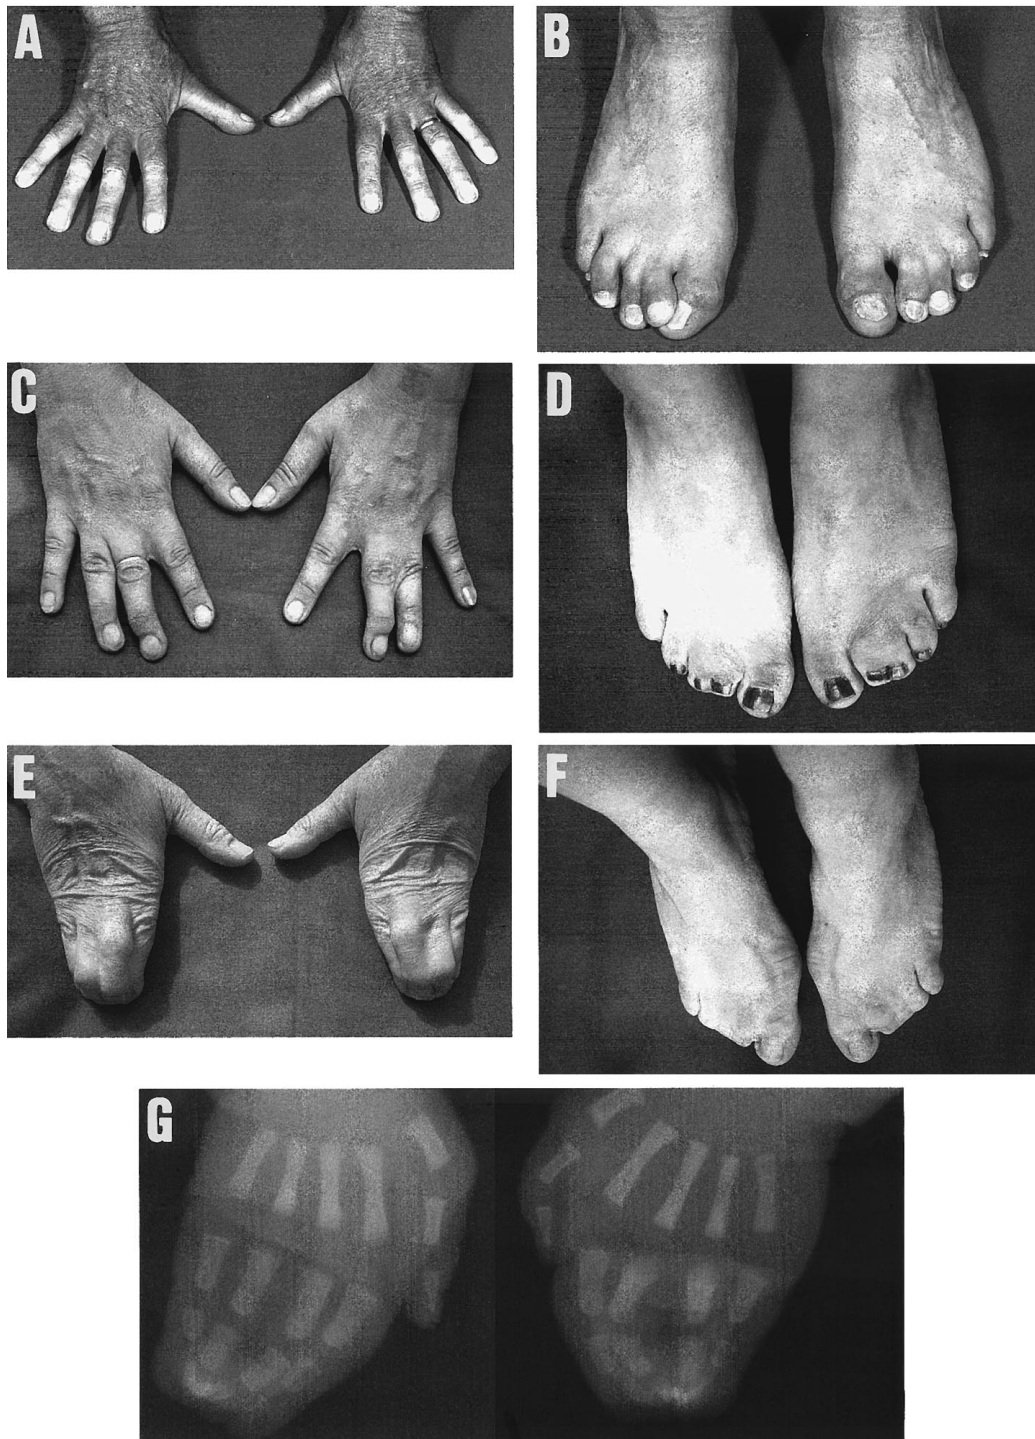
Phenotypic appearance of variably affected individuals. *A* and *B*, Hands and feet of individual VI:12, demonstrating a mild expression of SD1; the hands are unaffected, the feet show partial syndactyly between the second and third toes. *C* and *D*, Hands and feet of individual VII:11. Partial webbing is present between the second, third, and fourth fingers, more pronounced in the left hand than in the right hand. Both feet show complete syndactyly between the second and third toes and partial syndactyly between the third and fourth toes. *E* and *F*, Hands and feet of individual VI:2, demonstrating the most severe expression of SD1 in the family studied; complete webbing between the second to fifth fingers in both hands and syndactyly between the first to fourth toes in both feet. *G*, Radiographs of the hands of individual VII:2 taken shortly after birth. The distal phalanges of the third, fourth, and fifth fingers show a synostotic fusion in both hands.
